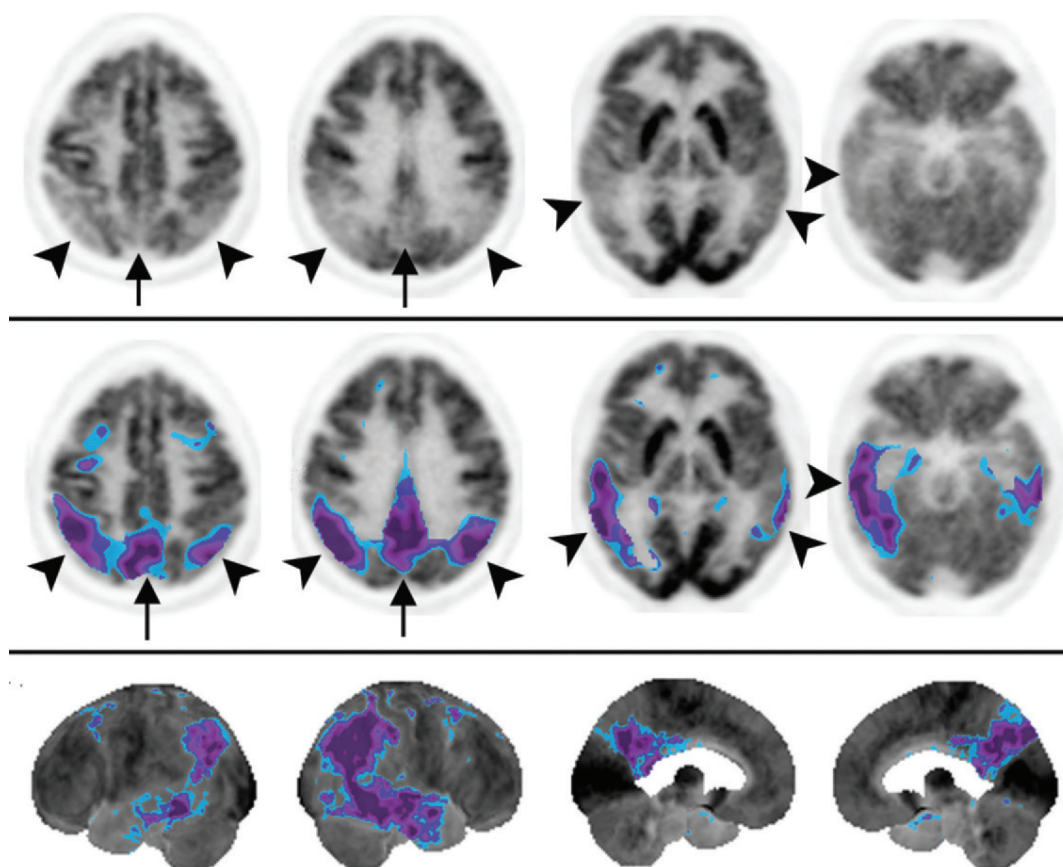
Alzheimer disease. Axial gray-scale FDG PET images (top), corresponding statistical thresholding overlay images (middle), and 3D stereotactic surface projection (SSP) images (bottom) (left to right: left lateral, right lateral, left medial, and right medial views) demonstrate bilateral hypometabolism in the parietotemporal cortices (arrowheads) and in the posterior cingulate-precuneus cortices (arrows), a pattern that is typical of Alzheimer disease. The posterior cingulate gyrus and precuneus are hypometabolic on the CAD images. Blue = -2 SDs, purple = -3 SDs. The earliest metabolic imaging biomarker of Alzheimer disease is often posterior cingulate gyrus hypometabolism. Although Alzheimer disease hypometabolism is frequently bilateral, defects are often asymmetric in extent and severity with respect to the left and right hemispheres; however, the posterior cingulate gyrus is usually involved. In more advanced Alzheimer disease, hypometabolism extends to involve the prefrontal association cortices as well. Metabolism is relatively preserved in the primary sensorimotor, visual, and anterior cingulate cortices, basal ganglia, thalamus, and posterior fossa structures in typical Alzheimer disease. In advanced disease, there may be frontal lobe involvement, but the anterior cingulate gyrus is spared.
